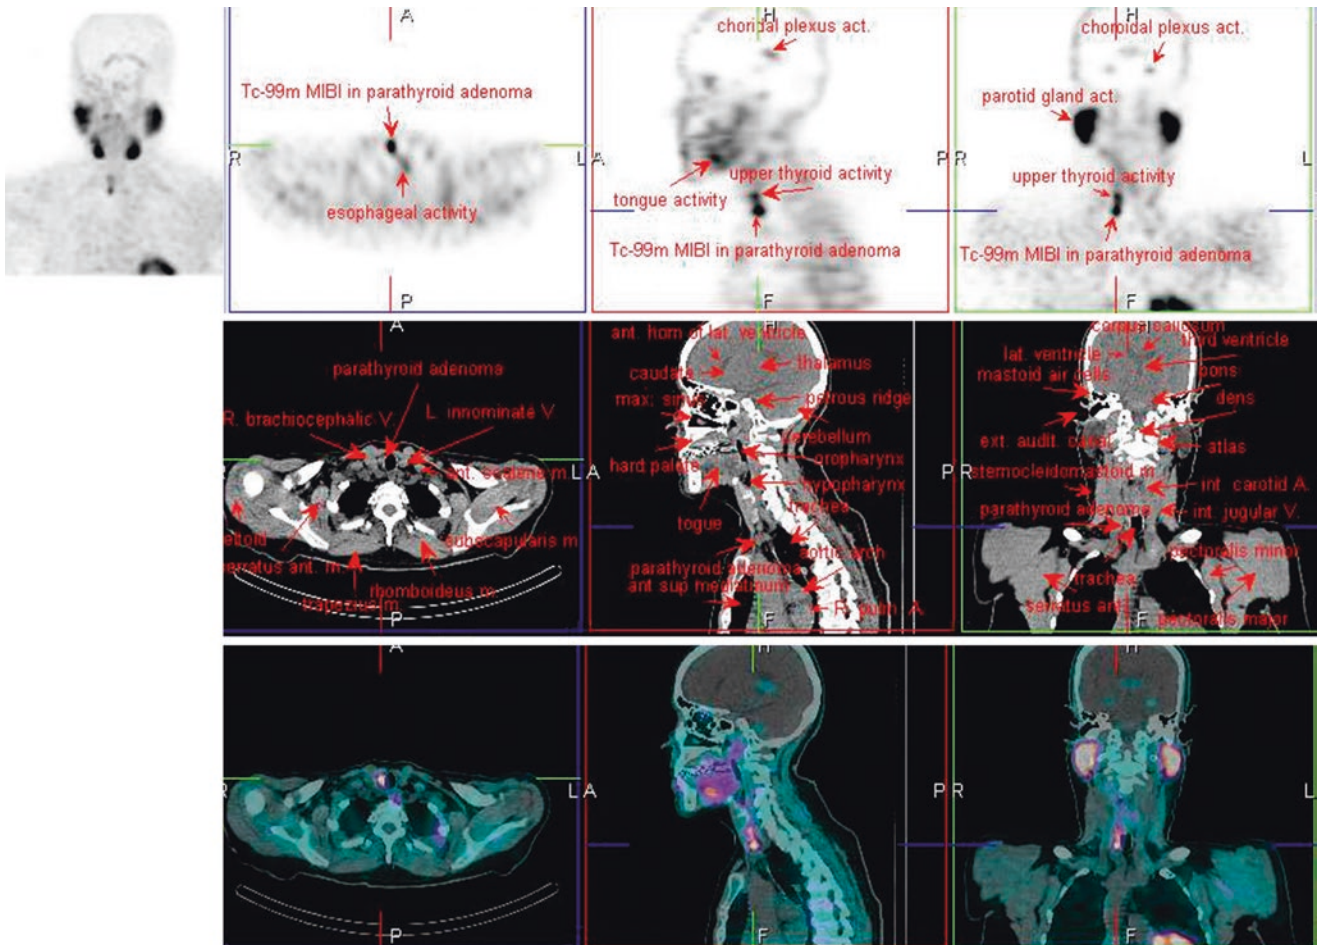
^{99m}Tc-MIBI SPECT/CT
